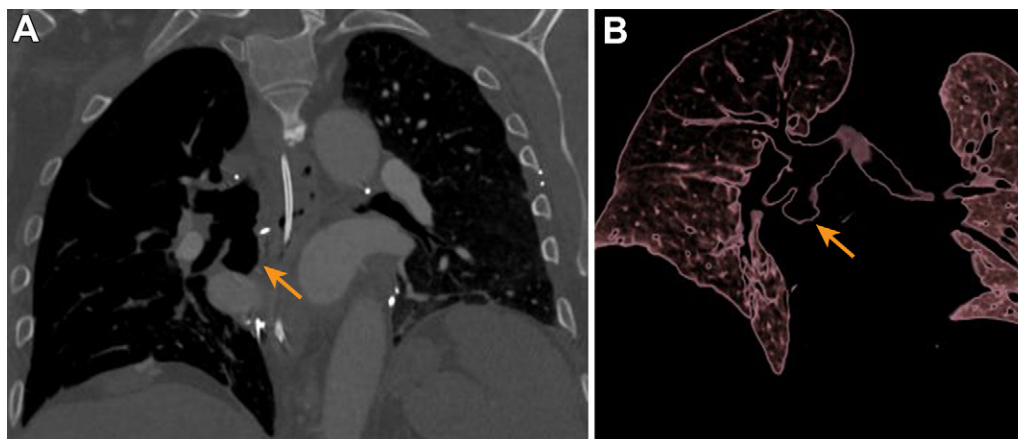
Images in a 48-year-old man with bronchial dehiscence 1 month after bilateral lung transplantation for idiopathic pulmonary fibrosis. (A) Coronal chest CT three-dimensional reconstructed minimum intensity projection image and (B) volume-rendered reformat image show outpouching (orange arrow) arising from inferior aspect of the bronchus intermedius adjacent to the surgical clips, compatible with bronchial dehiscence. Bronchial dehiscence was managed with endobronchial stent placement.
